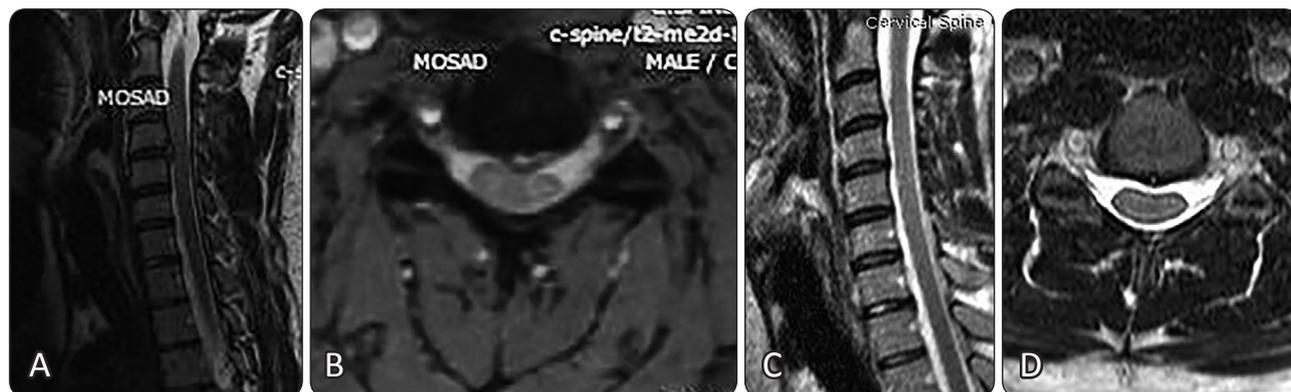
(A,B) Sagittal and axial T2WI MRI of the cervical spine images showed protruded disc fragment C4-5 level. (C,D) Sagittal and axial T2WI MRI after 6 months showed regression of the protruded disc fragment at the C4-5 level.
